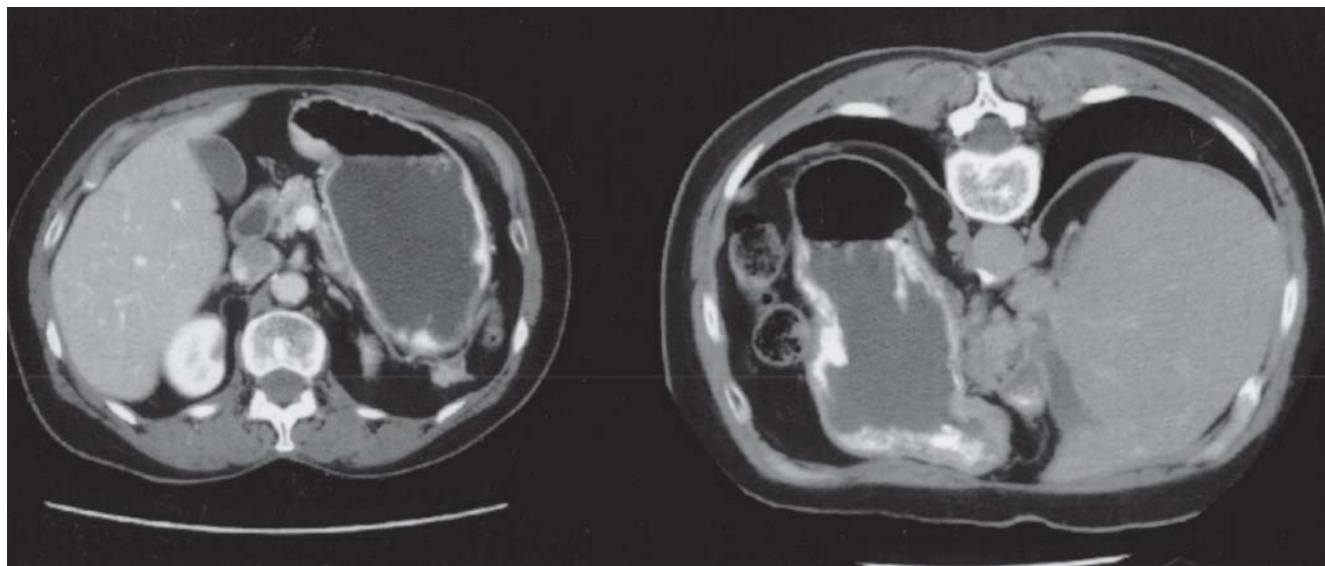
Shown is a computed tomographic scan of a patient with advanced gastric carcinoma. Water (a negative contrast agent) has been used to distend the stomach. The images were acquired with the patient in the prone position to allow the stomach to fall away from the retroperitoneum and to define the interface between the stomach and pancreas.
